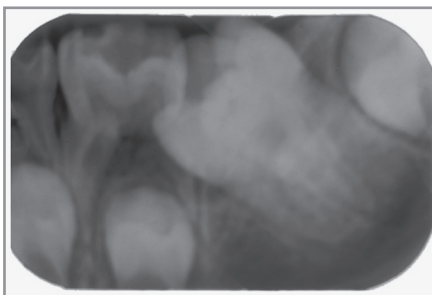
Periapical X ray shows a permanent first molar impaction and extensive distal root resorption of the primary mandibular left second molars. Used with permission.³
